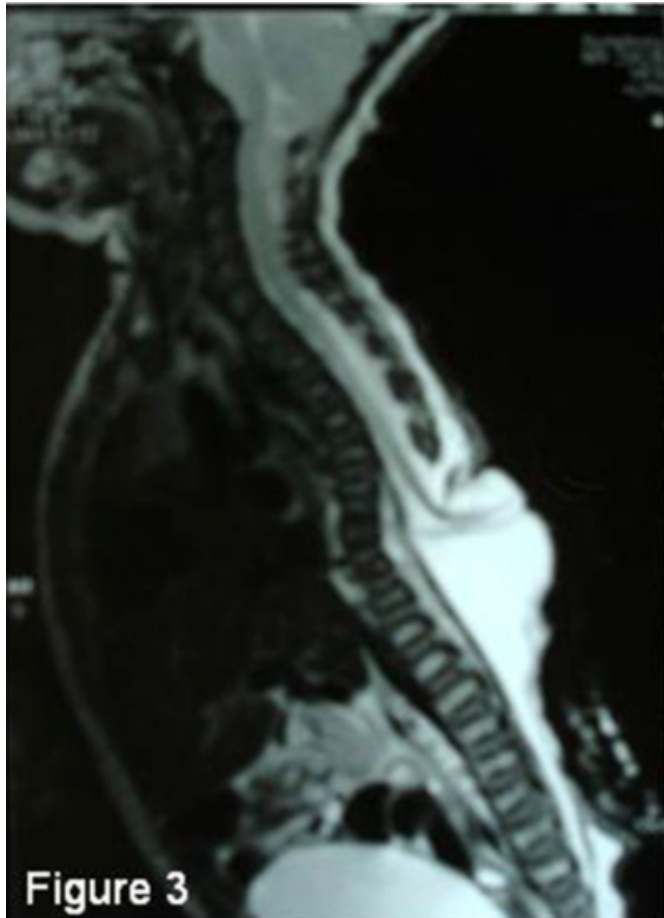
postoperative CT scan shows that hematoma was completely evacuated.
